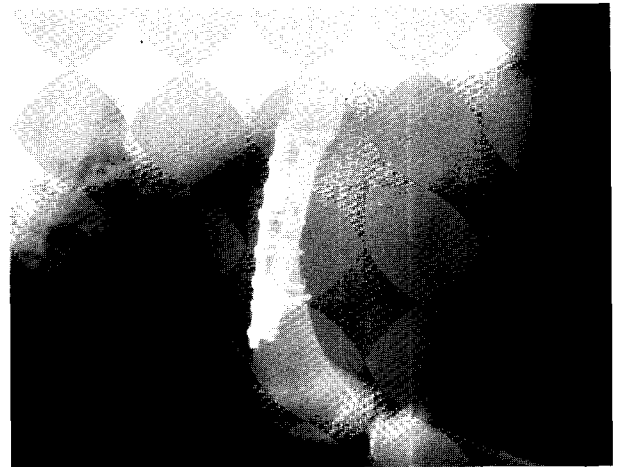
Lateral postoperative radiograph of the left femur following fixation with two lag screws and two neutralization plates. Again the thin cortex is noted.
